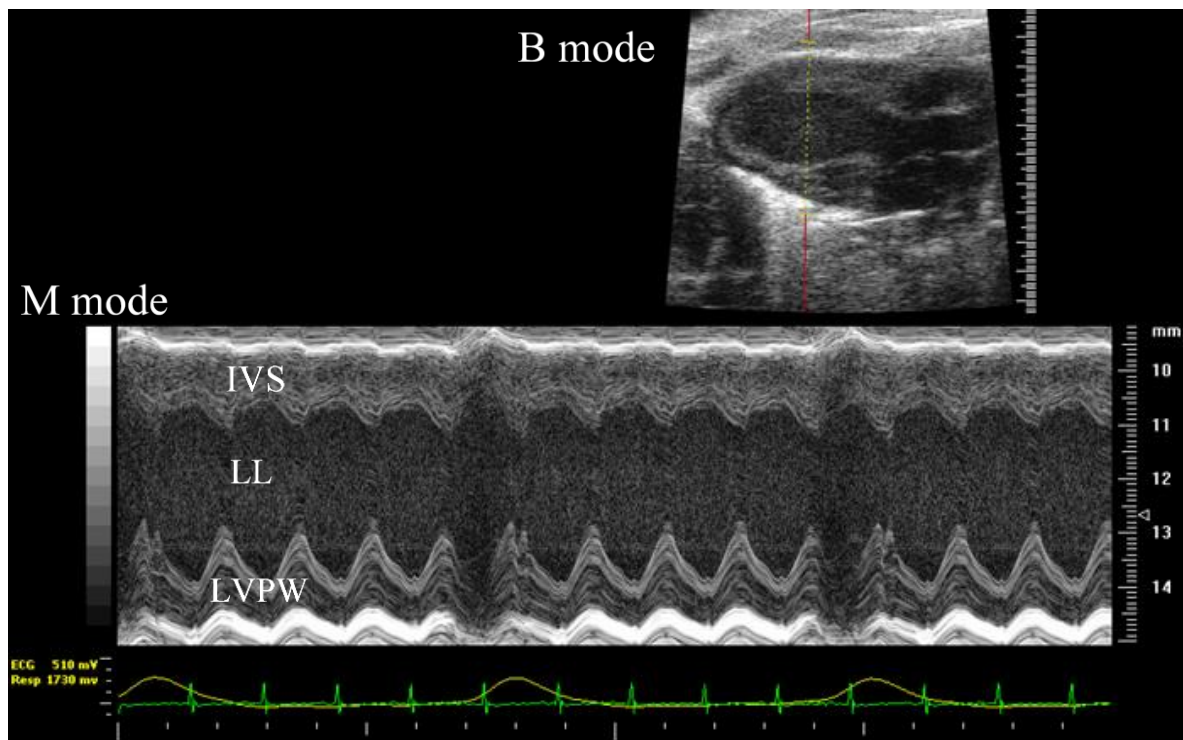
Representative image showing alignment of heart in B-mode and M-mode. B-mode was aligned in the parasternal long-axis view of the LV. Using the Vevo770 software an overlay was placed on the B-mode image equidistant between the apex and the start of the aorta opening. M-mode images were then captured from this position in the ventricle. IVS- Interventricular septum, LL- Left lumen and LVPW- LV posterior wall are labelled on the M-mode image.
